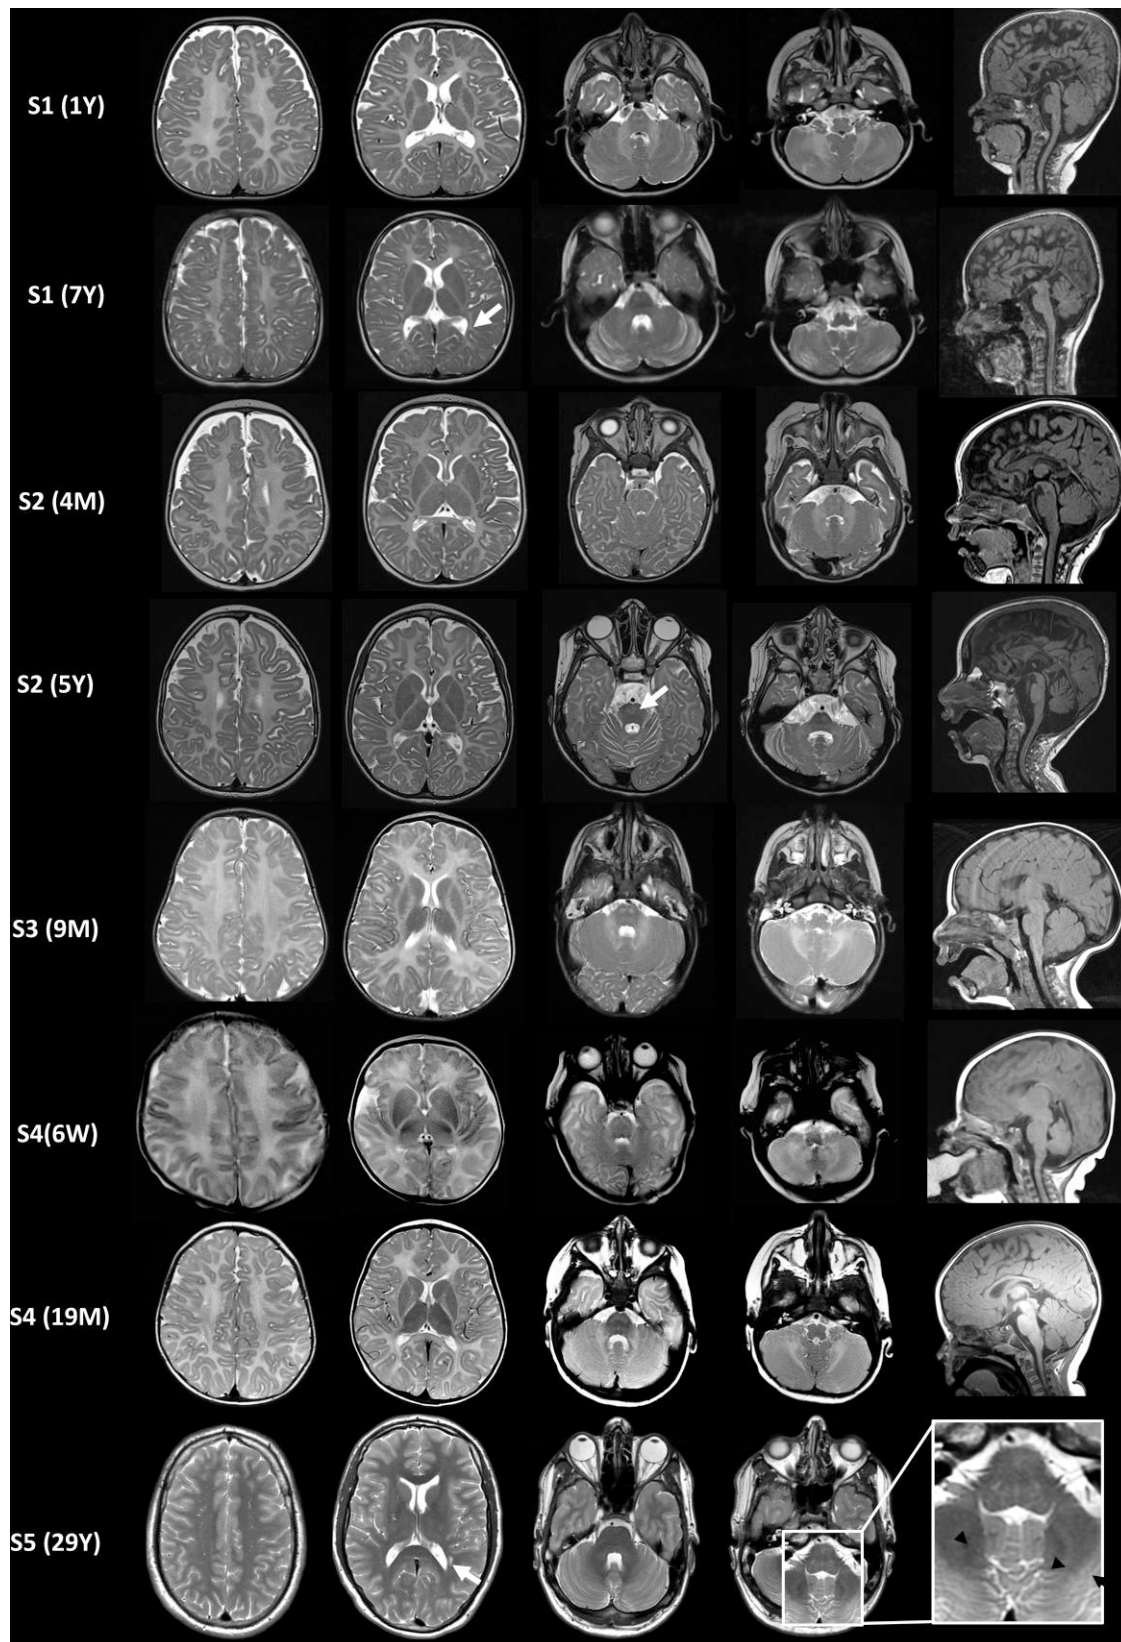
MRIs findings at different time intervals. Axial T₂-weighted and sagittal T₁-weighted images of S1–S5. S1–S4 show diffuse hyperintense signal in the supra- and infratentorial white matter suggesting hypomyelination. At the age of 7 years, S1 showed minimal progression of myelination in the middle cerebellar peduncles, the cerebellar white matter and the optic radiation (white arrow) and the corpus callosum was thin. MRI of S2 at age 5 years demonstrated improved myelination in the thalamus, cerebral peduncles, pons and medulla. MRI of S5 at age 29 years showed only a non-specific T₂-hyperintense signal abnormality in the parietal periventricular white matter (thick white arrow) and subtly elevated T₂ signal of the peridentate white matter including the hilus of the dentate nucleus (black arrows). Y = years; M = months; W = weeks.
